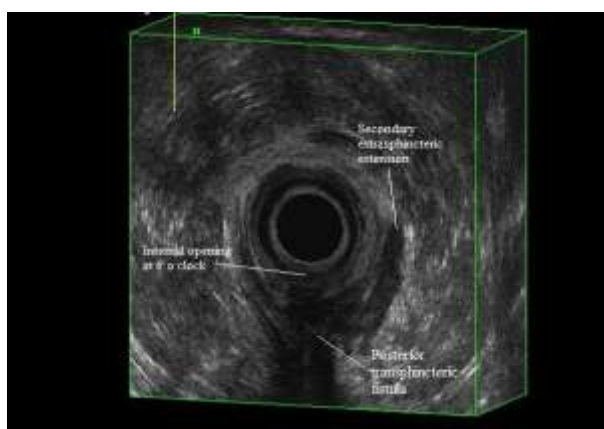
Unenhanced 3D Endoanal ultrasound scan image of posterior transsphincteric fistula with an internal opening at 6' o'clock and a secondary tract from 6' to 3' o'clock.
